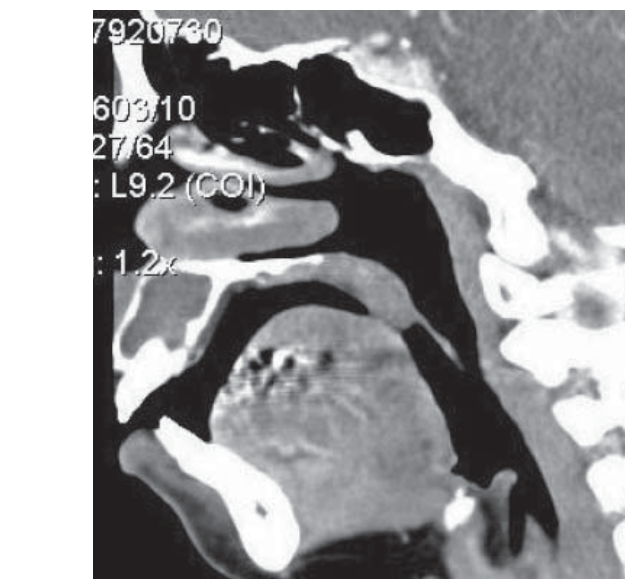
A sagittal cut of a contrast-enhanced CT displaying superior extension of the lesion with no soft-tissue involvement.
